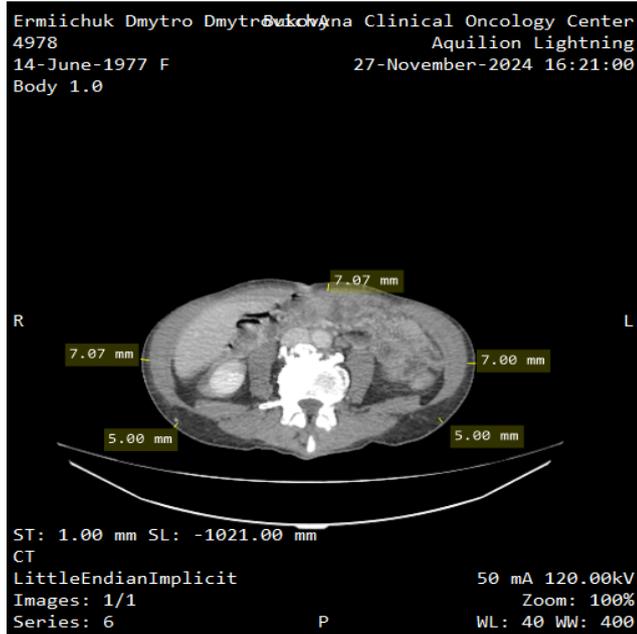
CT scan of patient E., 47 years old with normal body weight, performed at the level of the navel. The thickness of the subcutaneous fat tissue is from 5.0 to 7.07 mm.
